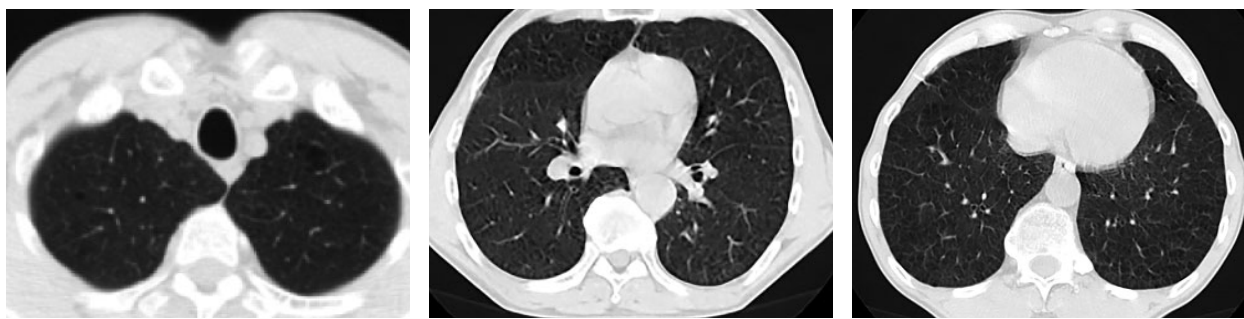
Computed tomography of the chest cavity dated January 16, 2024
